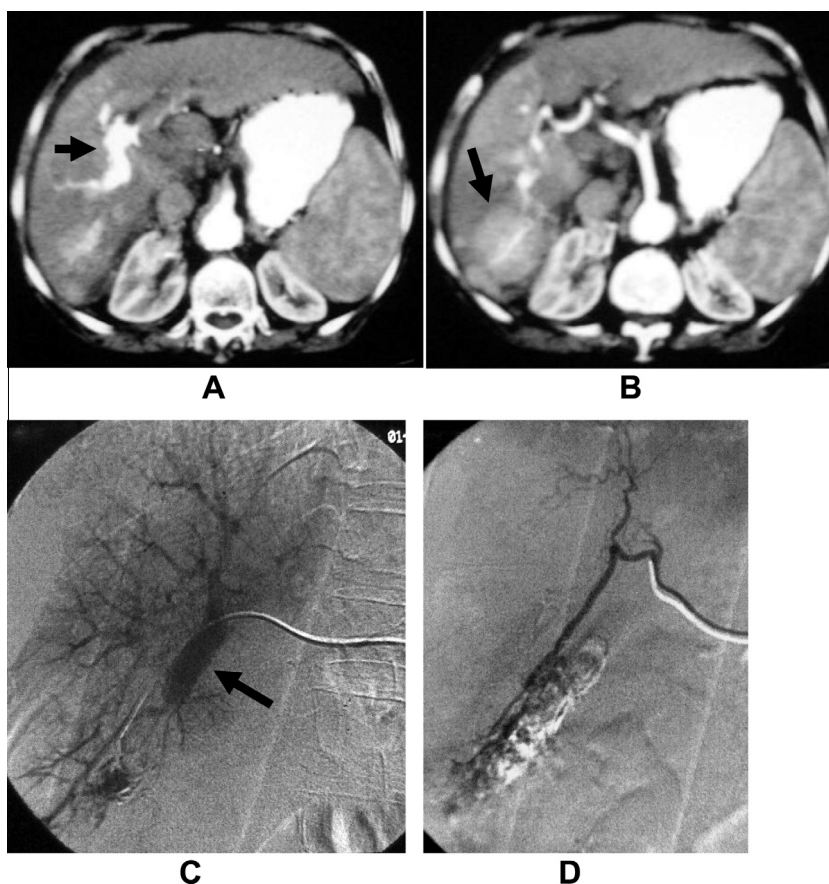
Central severe fistula: 56 year old male patient with liver cirrhosis and large posterior right hepatic lobe HCC at segment VI. (A and B) Axial sequential CT cuts show marked enhancement of the right portal vein during the early arterial phase (arrow in A) and the hepatoma (arrow in B). (C) DSA of the right hepatic artery confirms the presence of the fistula with filling of posterior branch of the right portal vein (arrow). (D) Super selective hepatic arteriogram after embolization of the fistula using N-butyl-2-cyanoacrylate (Histoacryl®) with no filling of the right portal vein.
